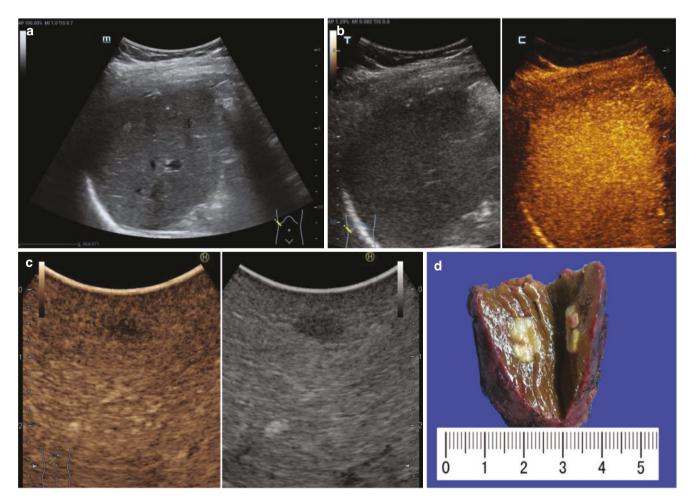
Detection of invisible HCC recurrence by intraoperative contrast enhanced ultrasound with injection of Sonazoid. A suspected recurrent HCC could not be detected by B mode ultrasound (a), neither
